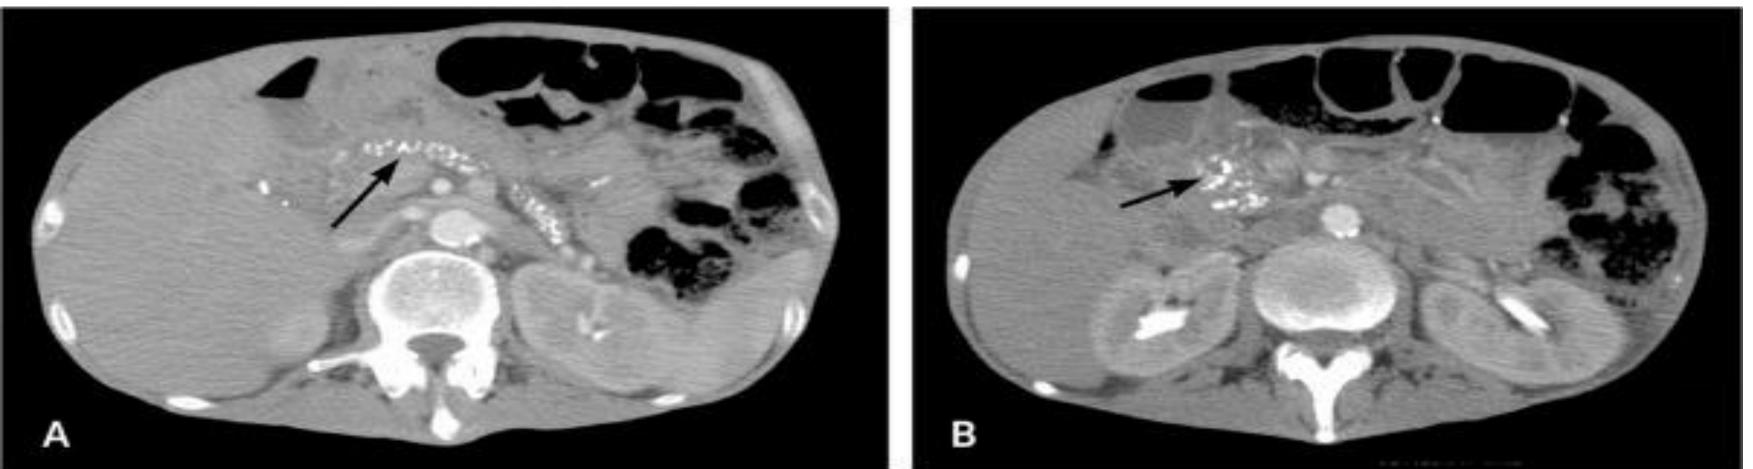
CT, Enhanced contrast computed tomography of the upper abdomen showing (A) pancreatic calcification (arrow) with fluid and edema around the pancreas; and (B) pancreatic calcifications (arrow) with fluid and edema around the head of the pancreas. Conclusions: The diagnosis of CP includes a wide range of clinical, laboratory, imaging investigations which provide truthful information about the degree of damage to the pancreas, the severity of morphological changes in the pancreas and allows the application of an appropriate curative treatment.
